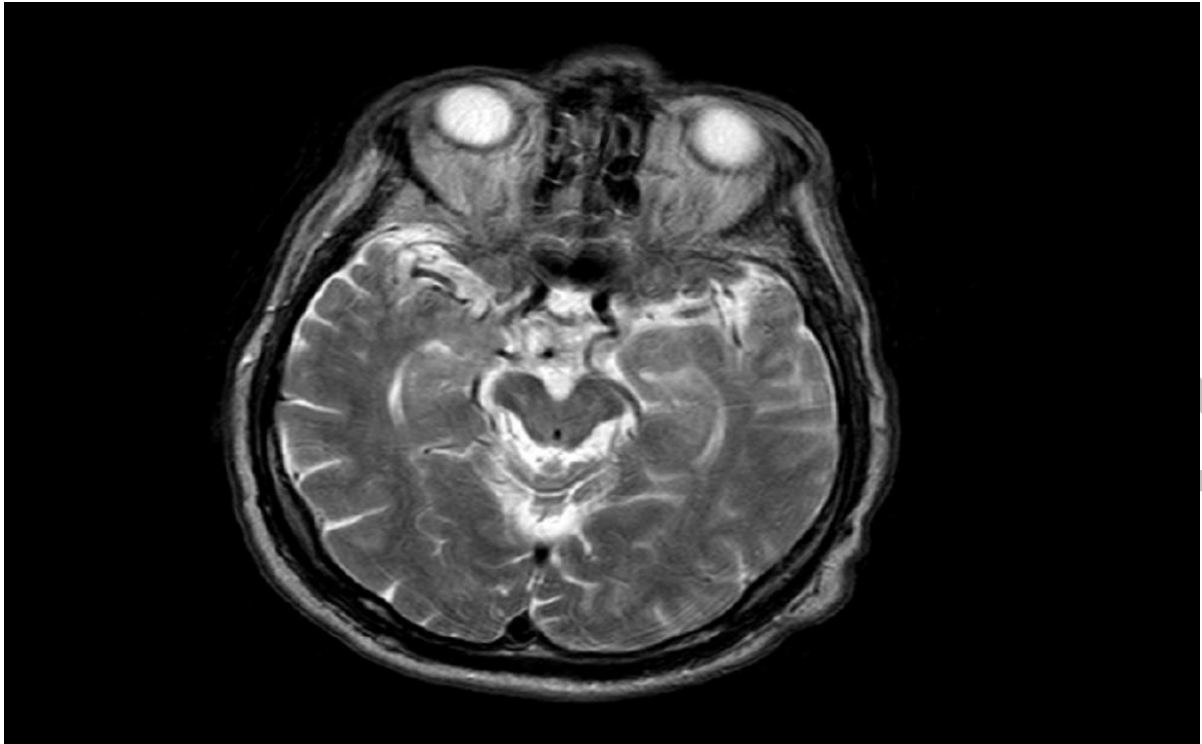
Magnetic resonance imaging shows significant atrophy with concave edges of the mesencephalon
